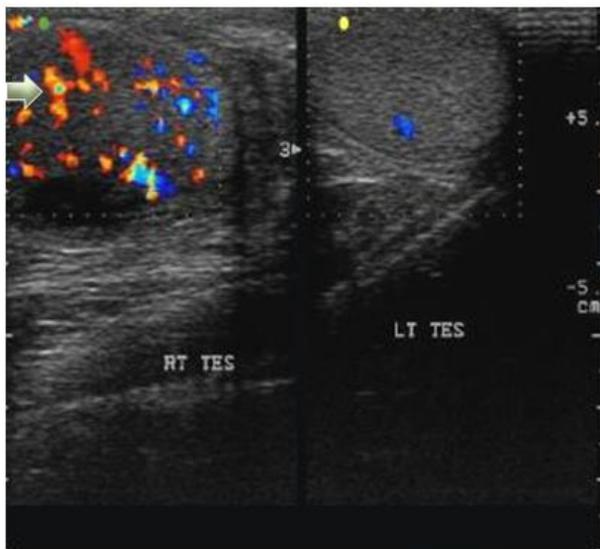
b: Colour Doppler shows increase blood flow (Colour doppler image)
